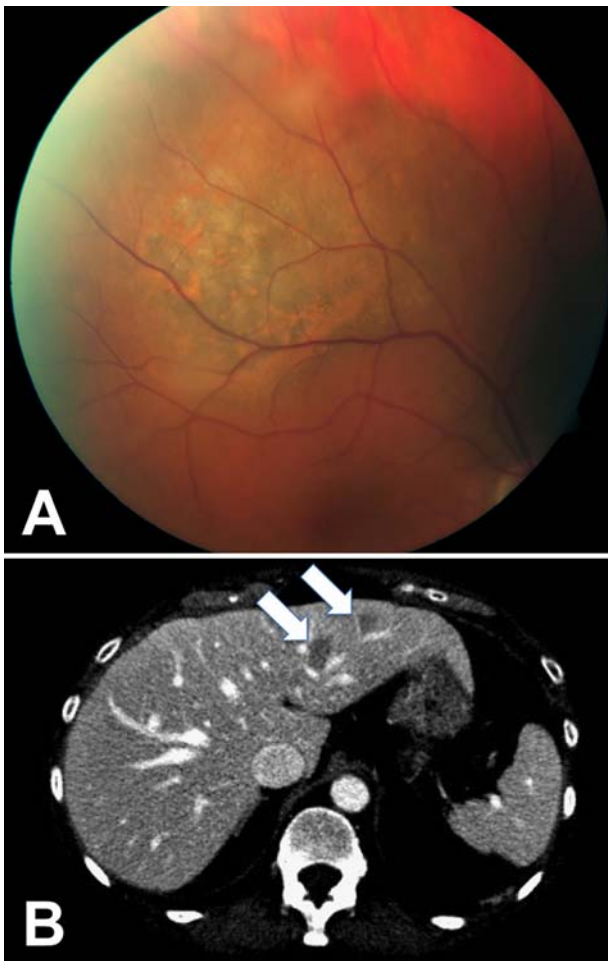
A, Right eye fundus photograph shows choroidal melanoma classified as T1 N0 M0 tumour. B, Abdominal computed tomography scan shows 2 hepatic lesions that were proved on biopsy to be metastatic melanoma.
